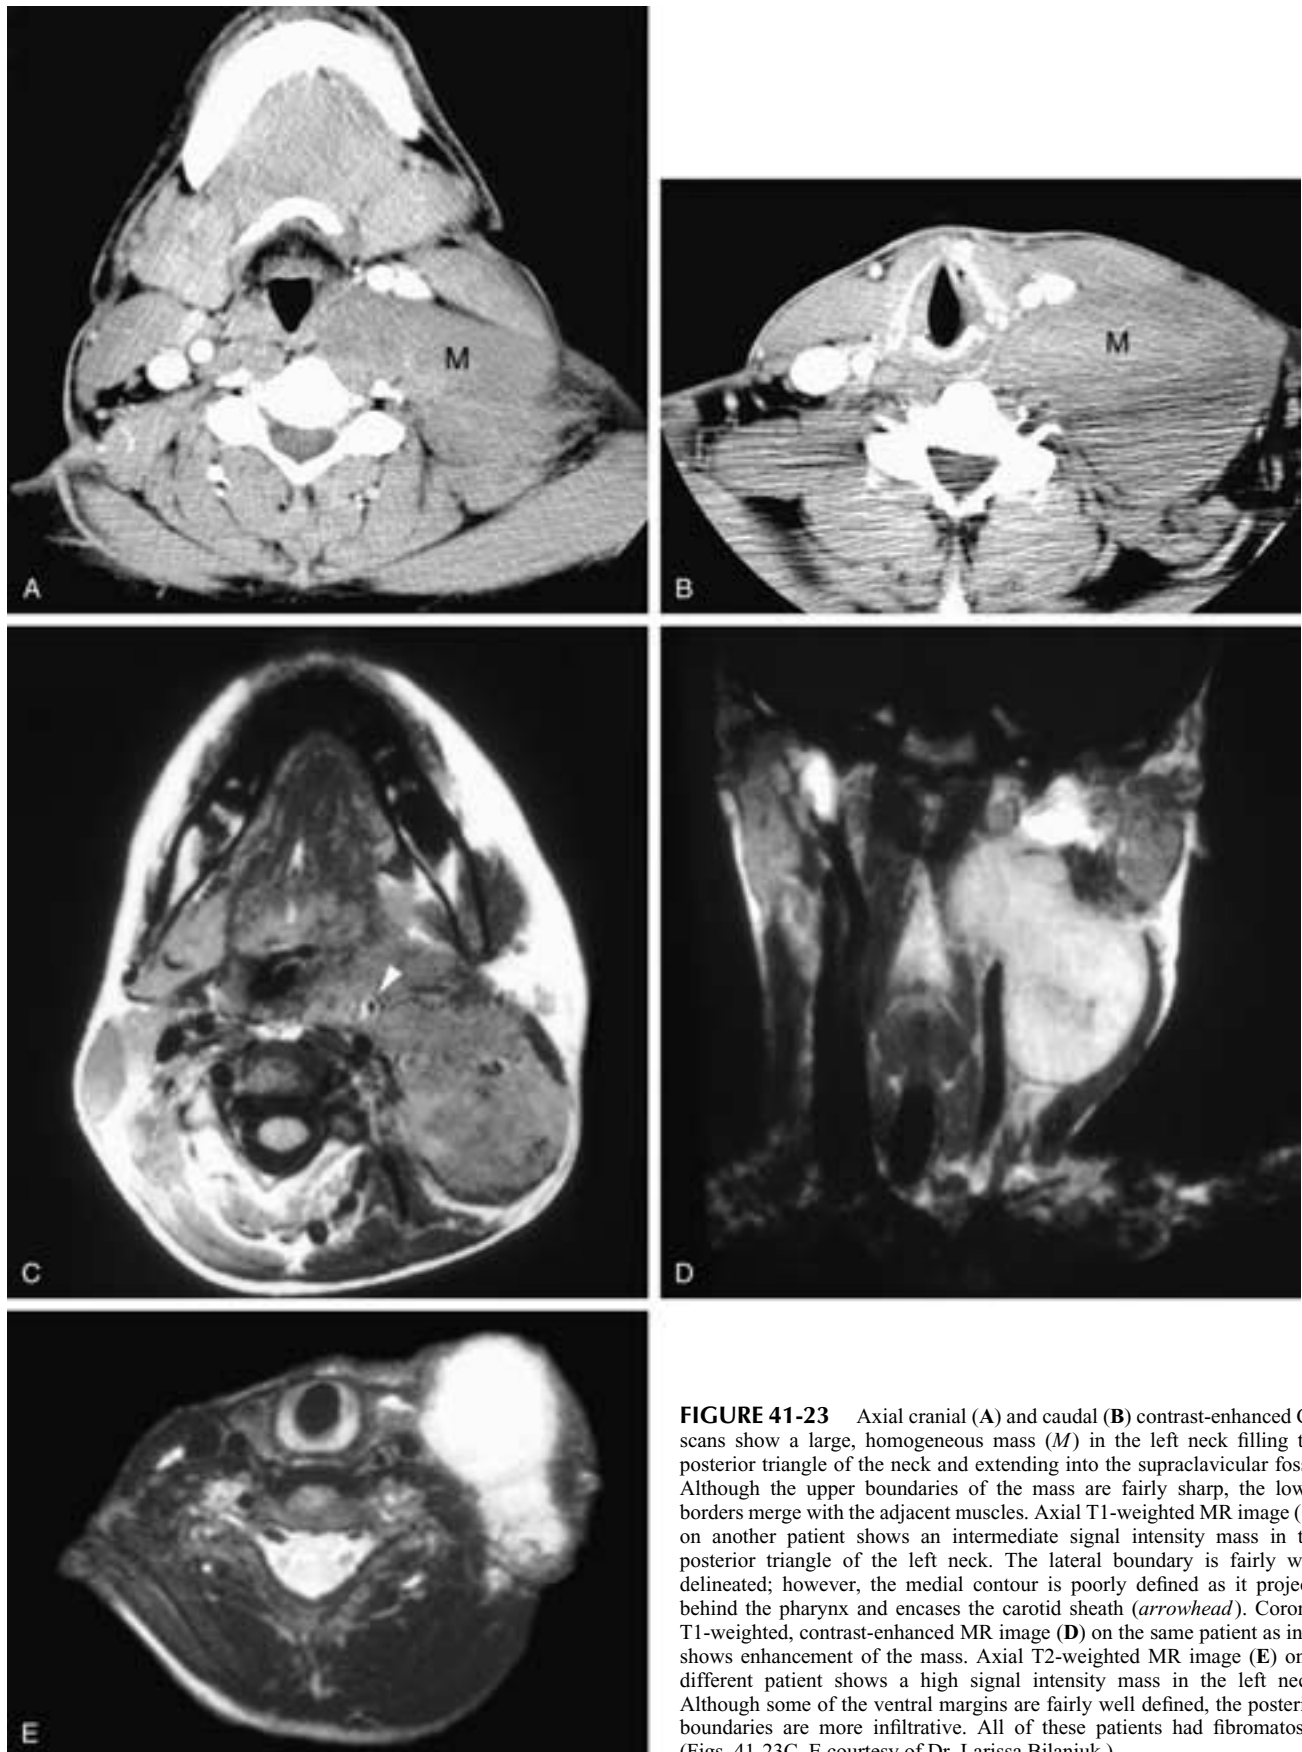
Axial cranial (A) and caudal (B) contrast-enhanced CT scans show a large, homogeneous mass (M) in the left neck filling the posterior triangle of the neck and extending into the supraclavicular fossa. Although the upper boundaries of the mass are fairly sharp, the lower borders merge with the adjacent muscles. Axial T1-weighted MR image (C) on another patient shows an intermediate signal intensity mass in the posterior triangle of the left neck. The lateral boundary is fairly well delineated; however, the medial contour is poorly defined as it projects behind the pharynx and encases the carotid sheath (*arrowhead*). Coronal T1-weighted, contrast-enhanced MR image (D) on the same patient as in C shows enhancement of the mass. Axial T2-weighted MR image (E) on a different patient shows a high signal intensity mass in the left neck. Although some of the ventral margins are fairly well defined, the posterior boundaries are more infiltrative. All of these patients had fibromatosis. (Figs. 41-23C–E courtesy of Dr. Larissa Bilaniuk.)
